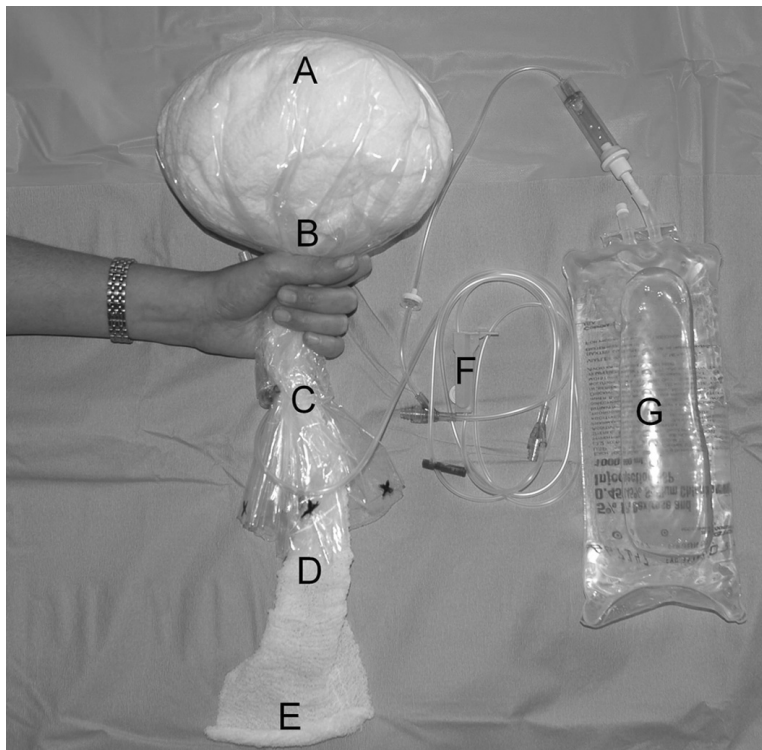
Photograph of a pelvic pressure pack, as constructed from an X-ray cassette drape, sterile gauze rolls, and an intravenous infusion set-up. Please see text for further explanation
